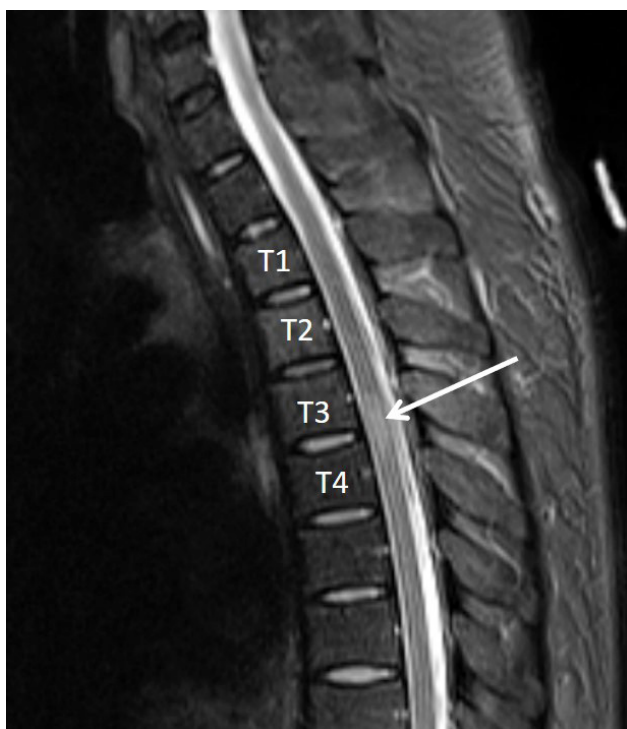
Magnetic resonance imaging of the thoracic spine. White arrow indicates T4 spinal cord contusion.
